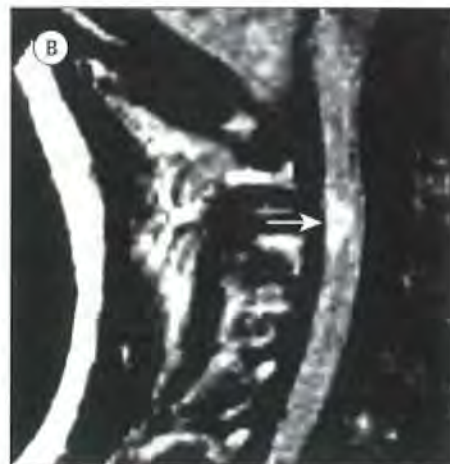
T₂-weighted scan. (A) Axial and (B) sagittal MRI showing a posterior cervical cord lesion (arrows) in a multiple sclerosis patient with deafferentation of the upper limb (useless hand of Oppenheim).
